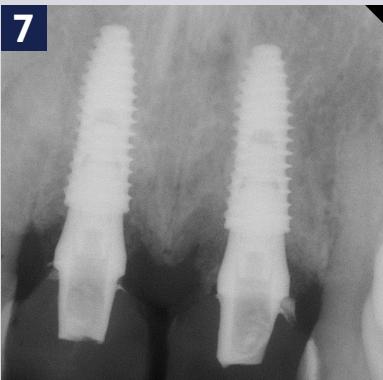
Immediate postoperative periapical radiograph showing the ideal implant position and abutments in place.
